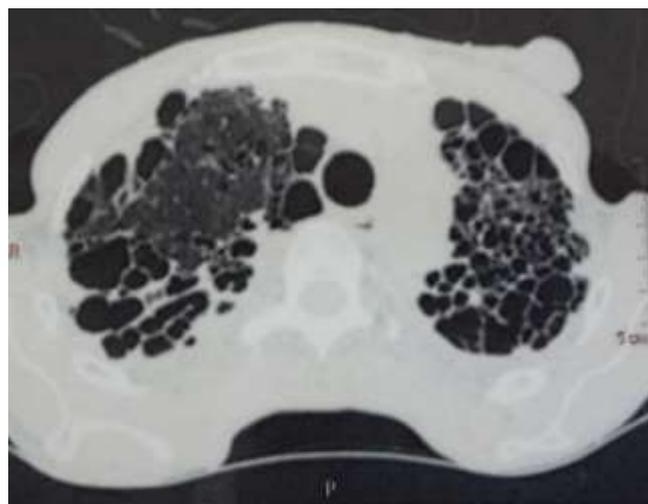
High resolution computed tomography of thorax shows bilateral diffuse cystic changes along with a cutaneous tag.
